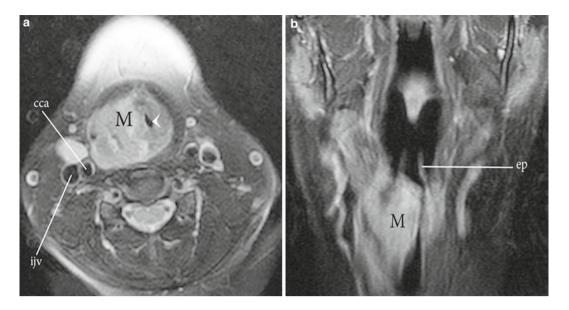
Laryngeal SCC. Axial (a) and coronal (b) fat suppressed T2-weighted MR images demonstrate a hyperintense right supraglottic and glottic mass (M), compressing the airway (*arrow*). Common carotid artery (*cca*, a), internal jugular vein (*ijv*, a), epiglottis (*ep*, b)
